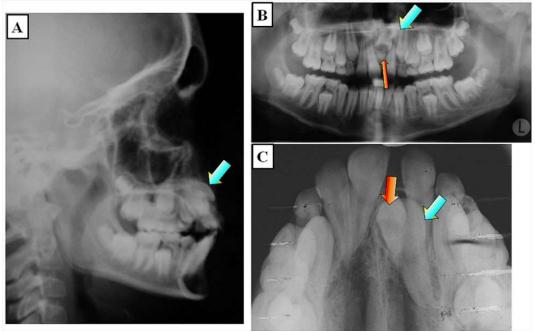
A-C: The radiographic images show the displaced and impacted tooth 21 (blue arrow) and the supernumerary tooth in the same region (red arrow).
